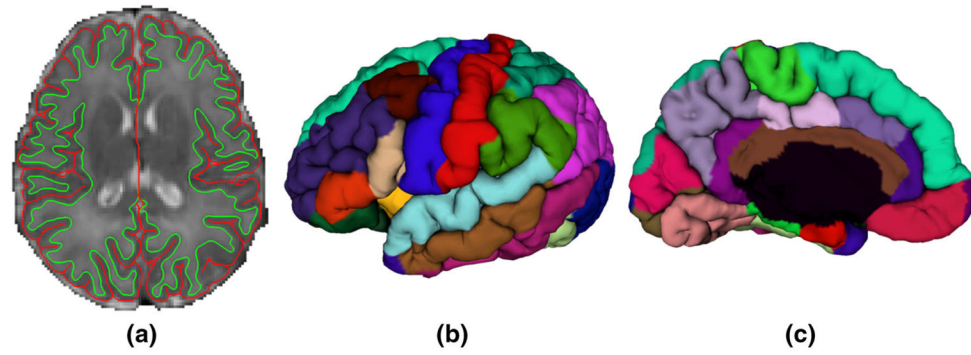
Cortical surface reconstruction and parcellation of a representative neonate. a Is an axial slice of reconstructed inner (*green color*) and outer (*red color*) cortical surfaces overlaid on the T2 MR image. b and c Are the lateral and medial views of the parcellation of the outer surface on the *left* hemisphere
